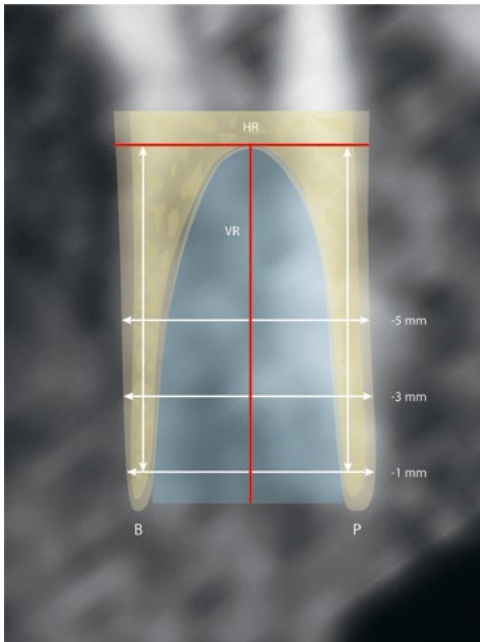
Horizontal and vertical radiographic changes. HR, horizontal reference line; VR, vertical reference line; B, buccal side; P, palatal side.
